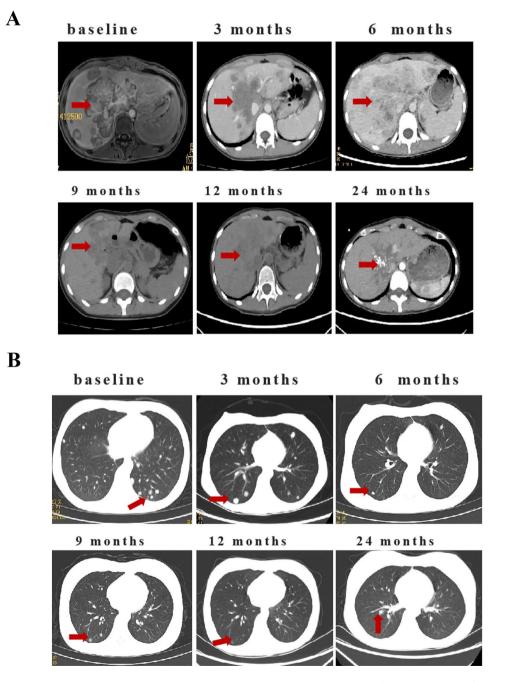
A. MRI of the abdomen showed multiple masses with a maximal 9.2 × 9.8 cm mass (red arrows) in the liver at the start of treatment (baseline). The low signal area in the abdomen CT showed gradual tumor shrinkage at 3 months, 6 months, 9 months, 12 months, 24 months after of treatment. B. Chest CT showed multiple pulmonary metastasis (red arrows) at the start of treatment (baseline). The hyperintensity gradually disappeared in lung sites in the early phase
